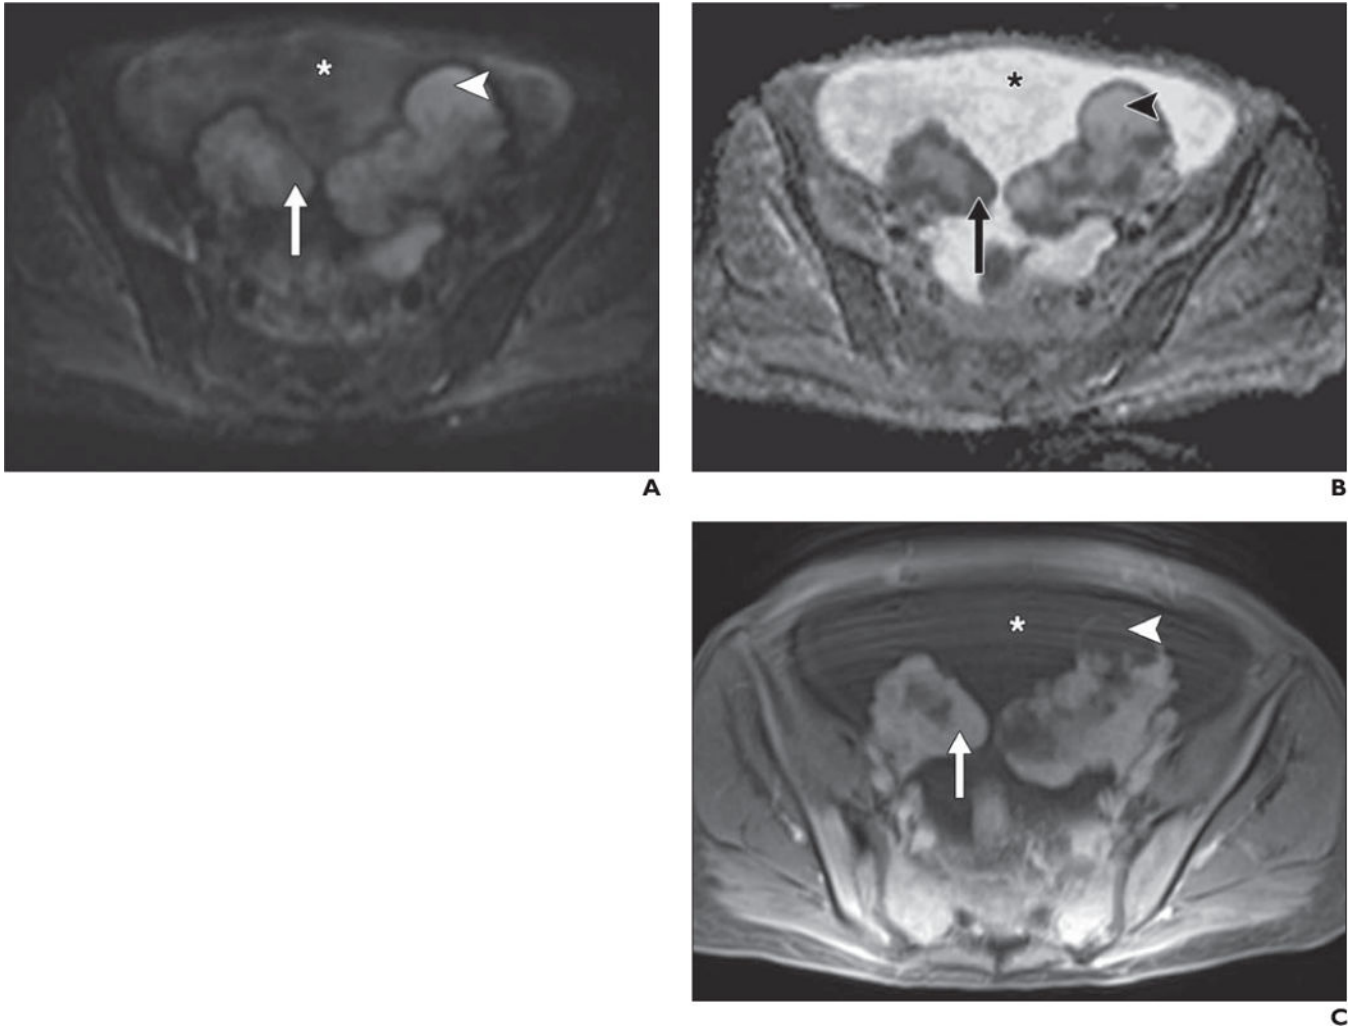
49-year-old woman with bilateral ovarian metastases from gastric adenocarcinoma (Krukenberg tumors). A–C, Diffusion-weighted image with b800 (A), apparent diffusion coefficient (ADC) map (B), and contrast-enhanced T1-weighted spoiled gradient-echo image (C) show solid enhancing components (compared with unenhanced image, not shown) in ovarian masses (*arrow*), high signal intensity on b800 images, and low signal intensity on ADC map. Surrounding ascites (*asterisk*) has intermediate signal intensity on high-b-value image and high signal intensity on ADC map, consistent with T2 shine-through on b800 images. Cystic portions of ovarian masses (*arrowheads*) also show high signal intensity on high-b-value image and ADC map but are not as hyperintense as surrounding ascites on ADC map, suggesting more complex (e.g., proteinaceous or hemorrhagic) fluid.
